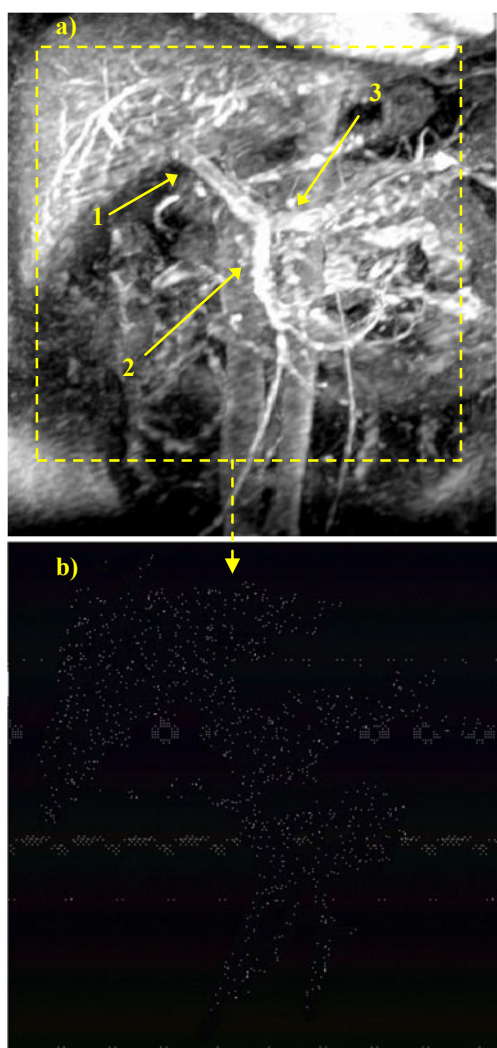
Portal vein system: a) MRI and b) 3D SolidEdge V20 reconstruction, 1 - portal vein, 2 - Superior mesenteric vein, 3 - Splenic vein
